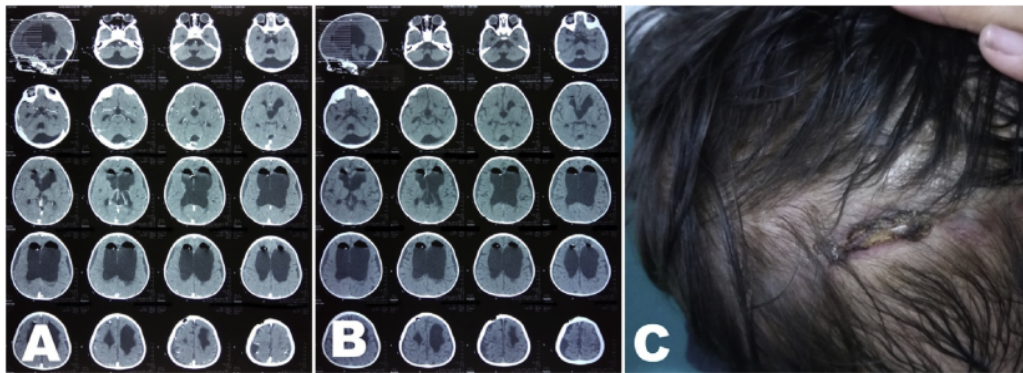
The first case, a three-year-old female, who had a diagnosis of hydrocephalus treated with ventriculoatrial (VA) shunt and had an exposed shunt; A and B Pre-procedural CT-Scan; C. Pre procedural clinical image showing tube protrusion on scalp.
